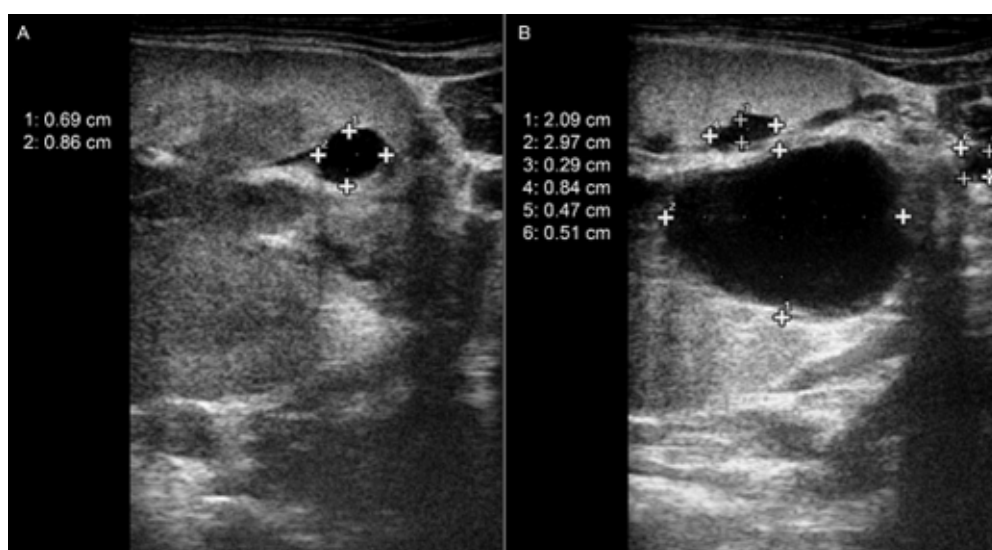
Findings of ultrasonography in October 2021. (A) A single cyst measuring 0.69 cm \times 0.86 cm was found in the right kidney. (B) Presence of multiple cysts of various sizes within the left kidney
